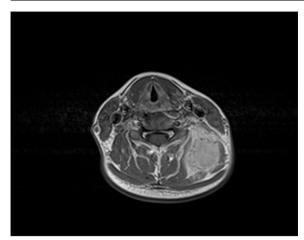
Axial, T1-weighted image reveals hyperintense SI of the lesion with a low-SI rim.
